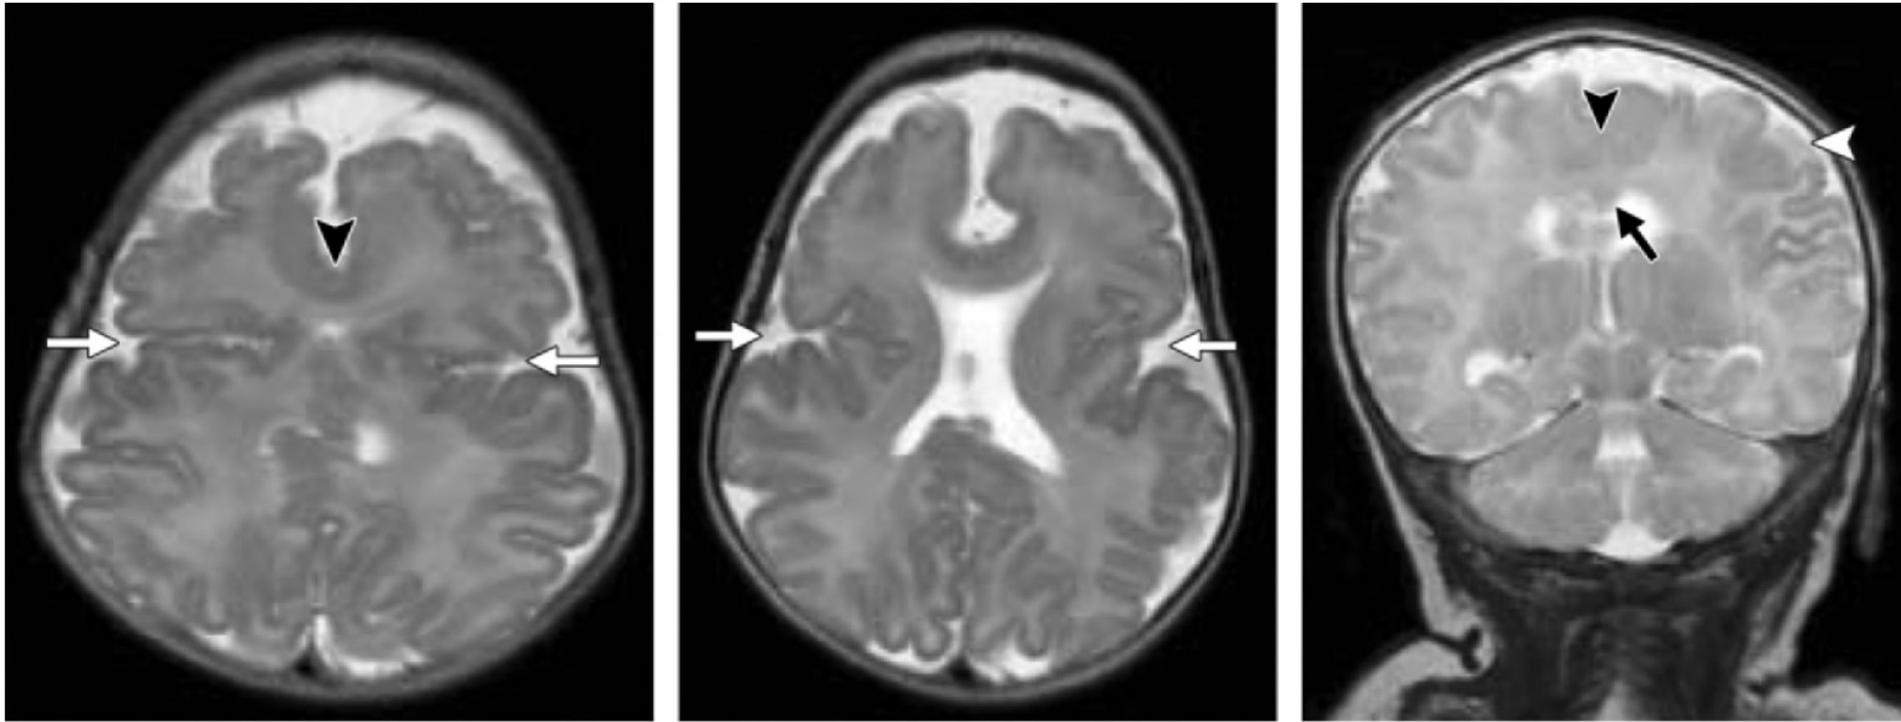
MIH. Axial T2-weighted half-Fourier RARE MR images obtained at 33 weeks estimated gestational age. Note the lack of midline separation in the posterior frontal and parietal areas (*), while rostral and posterior regions of the cerebrum are cleaved normally, and the orbits are spaced normally. Also, note the vertically oriented sylvian fissures (arrows), which abnormally connect across the vertex.
